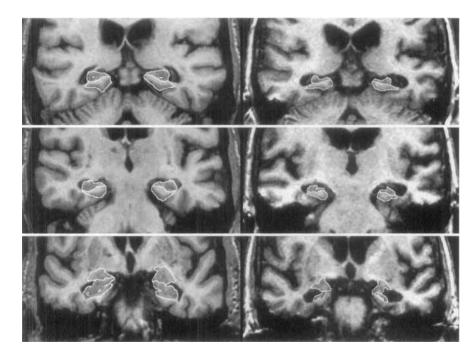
Neuroanatomic boundaries. Two columns of images are presented: cropped oblique coronal MR images through the temporal lobes of a 75year-old female control subject (left) and images from a 73-year-old female AD patient (right), CDR 1. In each column, three images are present. From top to bottom these represent sections at the level of the hippocampal tail, hippocampal body, and hippocampal head. The anatomic outlines of the hippocampus, and parahippocampal gyrus are indicated on images of the hippocampal head and hippocampal body. The outline of the amygdala and hippocampus are indicated in the bottom image of the hippocampal head. Neuroanatomic criteria employed when tracing the boundaries of these three medial temporal lobe structures are indicated in the text.
